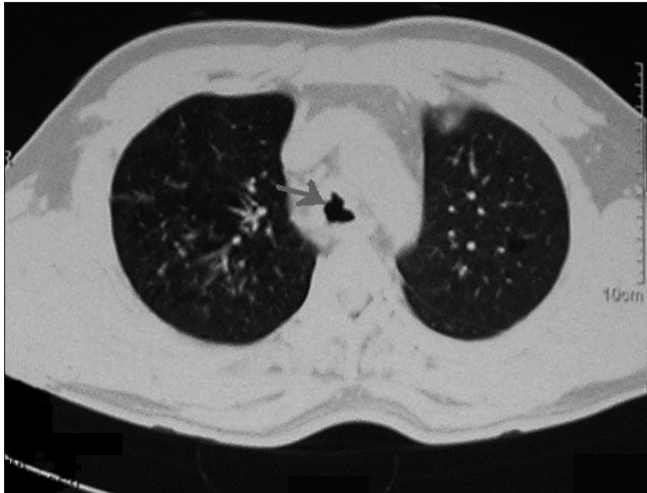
CT chest showing irregularity and abnormality of anterior wall of trachea
